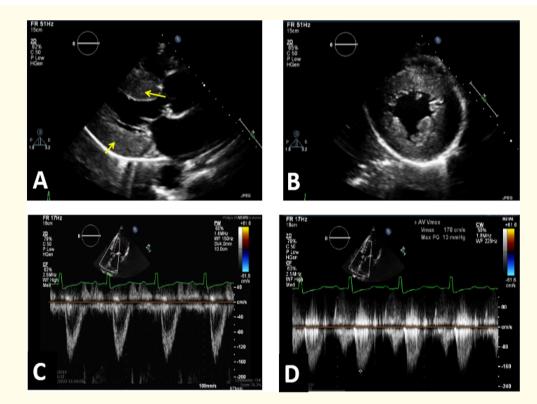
A, B: Parasternal long and short axis during systole demonstrates septal and posterior-lateral wall hypertrophy (IVSd-1.7 cm, LVPWd-1.7 cm respectively), yellow arrows. Using the previous dimensions as well as LVEDD-4.9 cm The LV mass as indexed to basal surface area (BSA) was calculated to be (LV mass = 202.6 grams/m^2) consistent with severe concentric LVH. C, D. The presence of LVOT obstruction is assessed by using pulse wave and continuous wave Doppler. In our patient, the peak velocities across the LVOT were within normal range < 2.7 m/s and Doppler wave forms were early-peaking. These findings exclude hypertrophic obstructive cardiomyopathy (HOCM).
